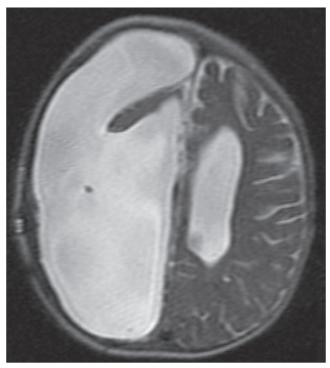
The magnetic resonance imaging scan of a patient who has undergone right hemispherectomy for intractable epilepsy is shown. A small tongue of disconnected frontal brain tissue remains. The patient's EEG is shown in the previous figure.
